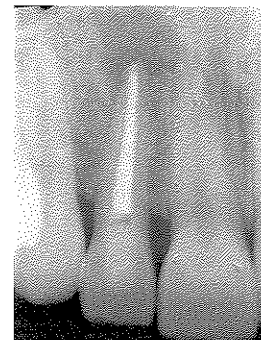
Periapical radiograph from the 10 months follow-up. There is no evidence of external cervical root resorption
